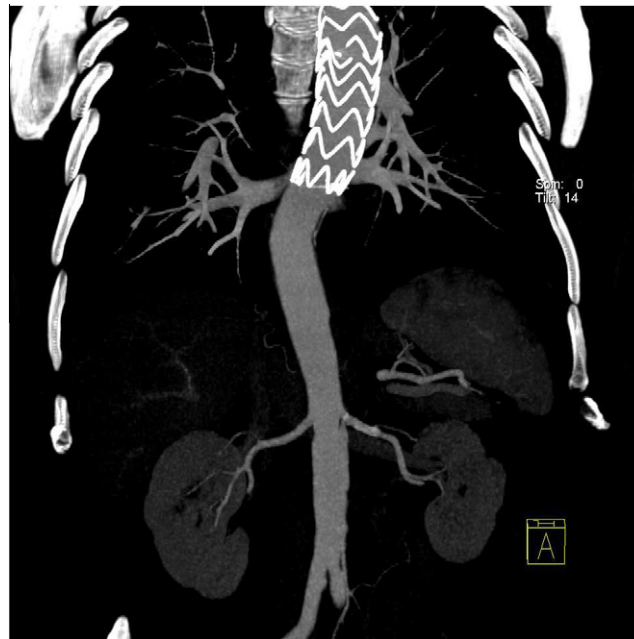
Third month CT aortography shows aortic graft stent and left kidney stents.
